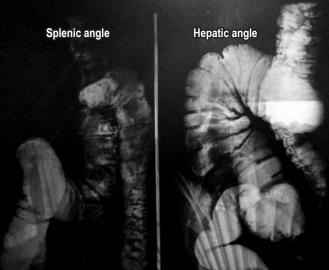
Abdominal barium enema radiography in standing anteroposterior projection shows evidence of colonic wall thickening, irregular dilations of the colonic frame, increased amounts of heterogeneous secretions in the ascending colon, hepatic angle, descending colon and sigmoid colon with multiple polypoid images and correlative signs with collar ulcers.
